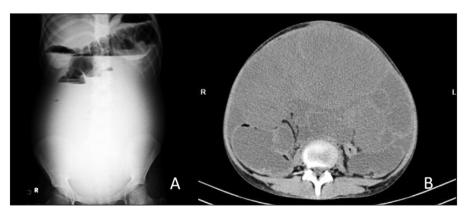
Air liquid level in direct standing abdominal X-ray (A). Abdominopelvic mass images in CT (B).
